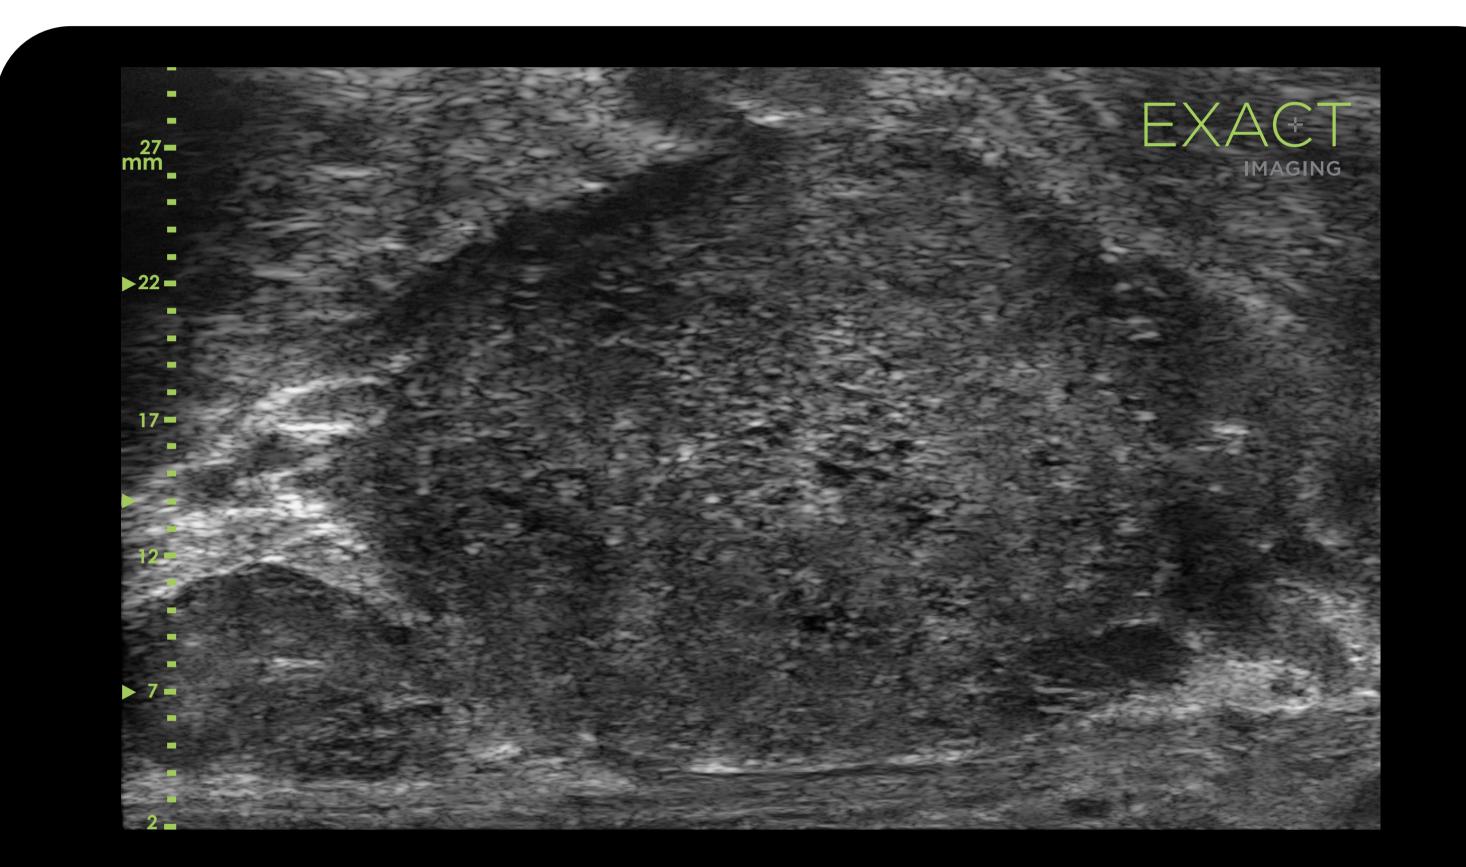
Lesion targeted by both MRI and micro-ultrasound at the Left Apex. This lesion was a PRI-MUS 4 and PI-RADS 5, and biopsy revealed a Grade Group 2 cancer.
